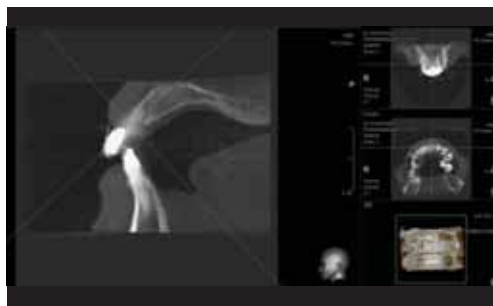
CBCT ASSESSMENT: BONE GRAFT POORLY INTEGRATED.
